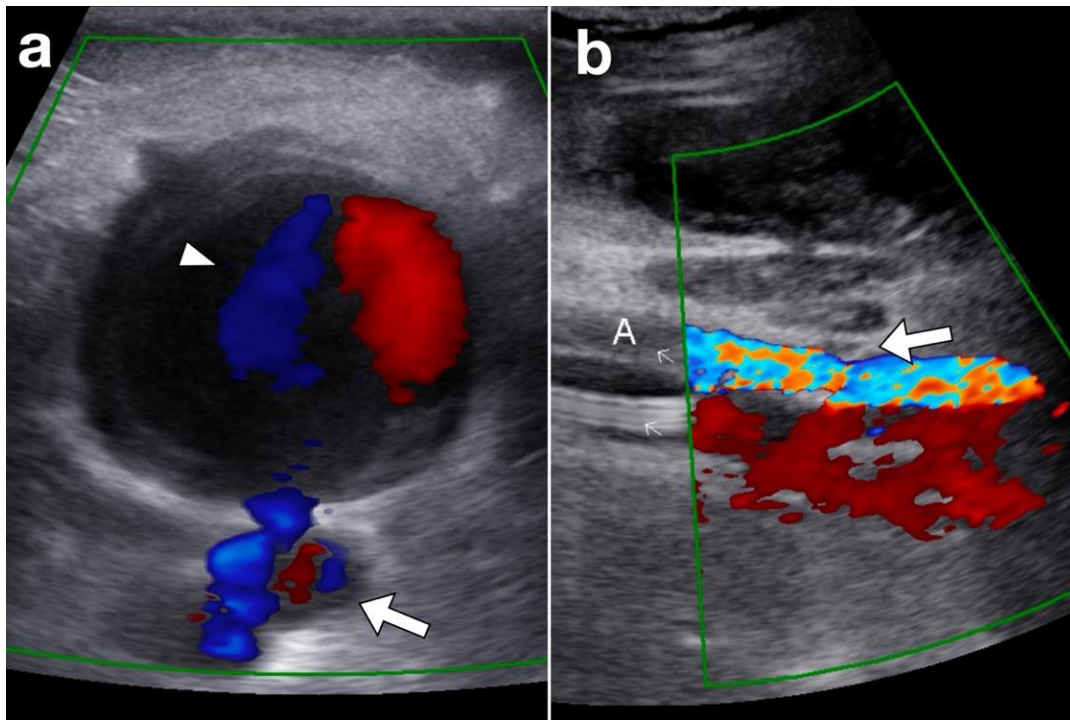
Ultrasound images of the SFA pseudoaneurysm. (a) The first ultrasound showed a multilobed pseudoaneurysm (arrow) with a yin-yang sign (arrowhead). (b) Post-balloon occlusion ultrasound on the next day showed complete thrombosis of the pseudoaneurysm and its neck
